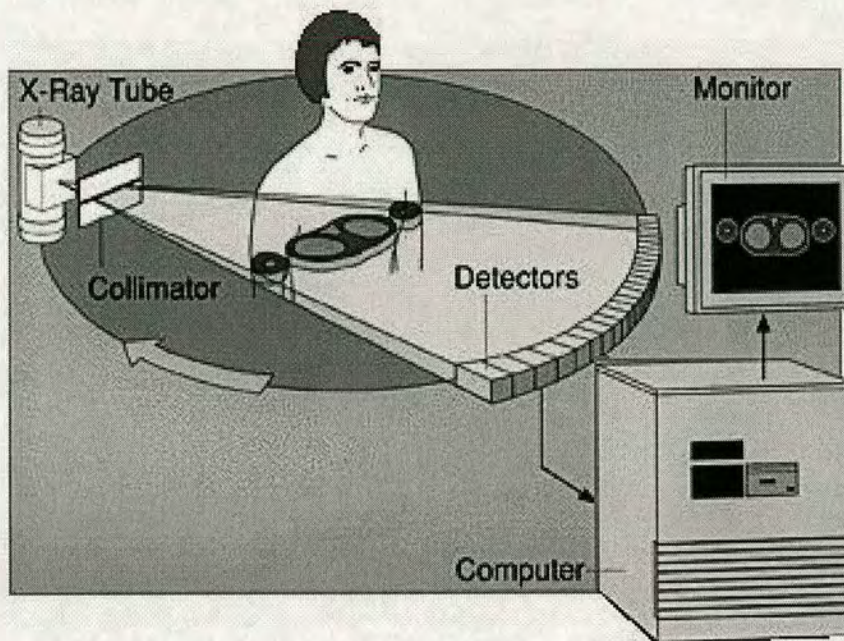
Relationship of X-Ray source, patient and X-Ray detector used in CT Imaging.
